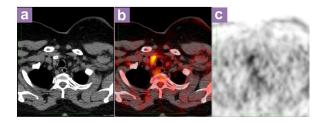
(a) Computed tomography, (b) fused and (c) positron emission tomography images of the thyroid incidentaloma.
